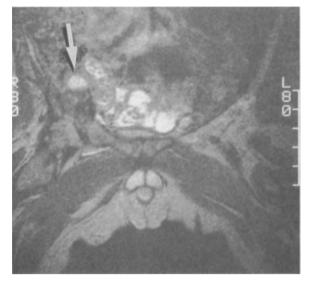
T2-weighted image in a newborn with bilateral hernias and bilateral undescended testes. The right testis is located in a typical intraabdominal location (*arrow*), as was proven surgically. The left testis is not shown. (MATTREY and TRAMBERT 1990)
